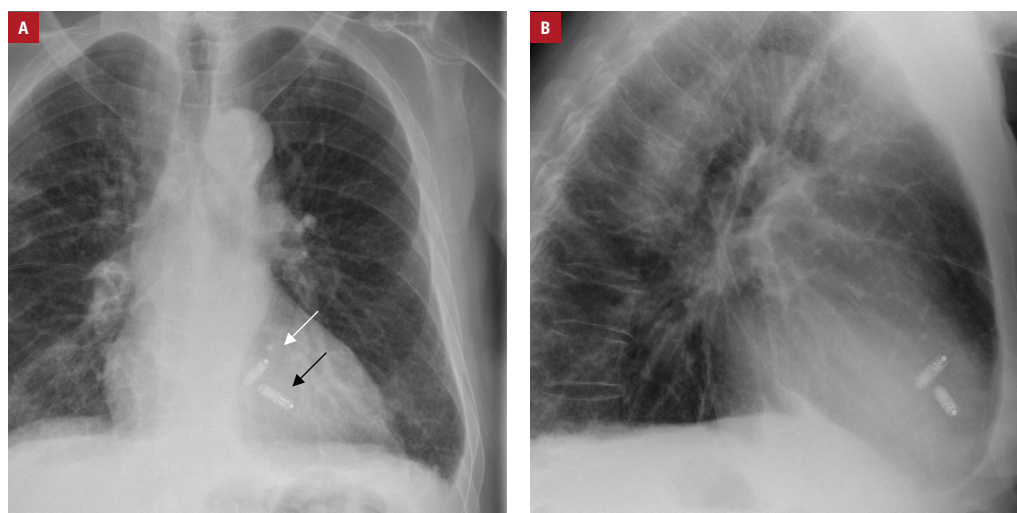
A – chest X-ray with the final position of the second Micra transcatheter pacing system (white arrow) and an older device (black arrow); B – chest X-ray: lateral view
